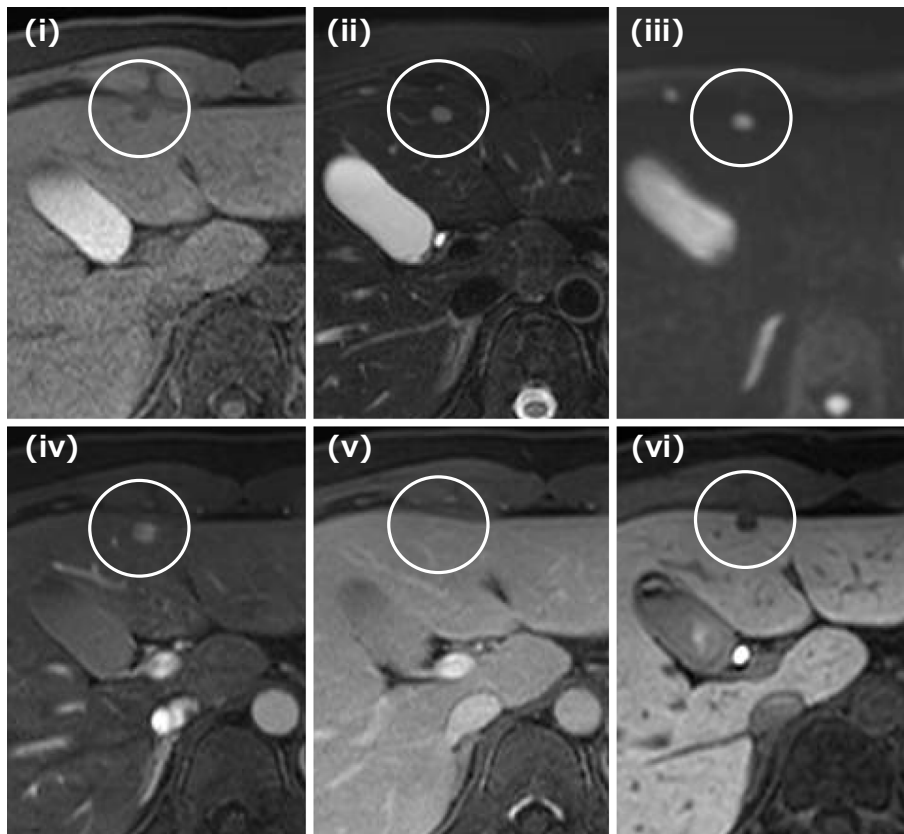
MRI showed low, high, and high intensity nodule in T1 (i), T2 (ii), and diffusion (iii) weighted images. Gd-EOB-DTPA-enhanced MRI showed hyper-enhancement in the arterial predominant phase (iv), iso-hypo-enhancement in the portal predominant phase (v), and defect in the hepatobiliary phase (vi).
